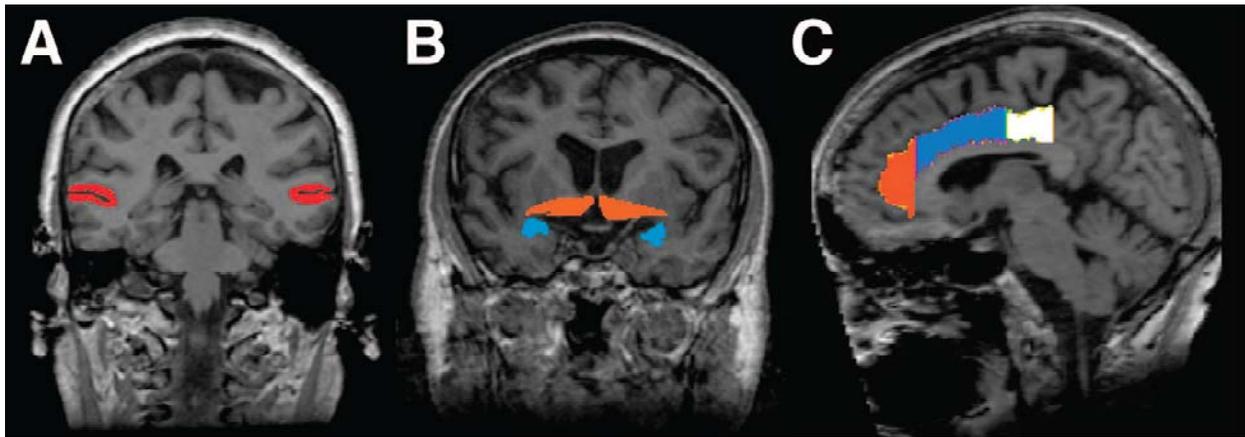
Locations of 6 VOIs defined on MR images used in SPECT-based discrimination tasks. (A) Banks of superior temporal sulcus (red). (B) Basal forebrain (orange) and amygdale (blue). (C) Rostral anterior cingulate gyrus (orange), caudal anterior cingulate gyrus (blue), and posterior cingulate gyrus (white).
